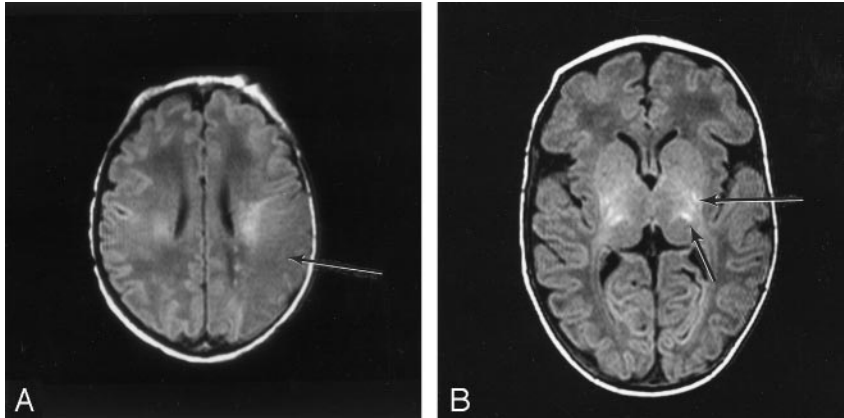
T1-weighted MR images (860/20).
